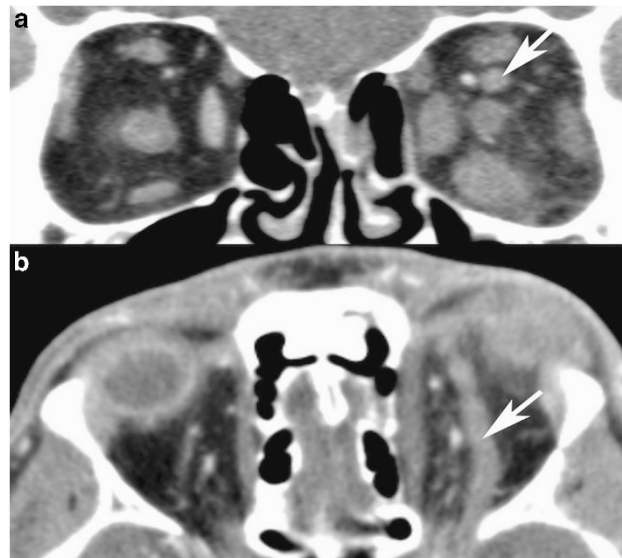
(a and b) Case 3. Axial and coronal CT revealing enlarged and thrombosed left SOV (arrow) and diffusely enlarged extraocular muscles.
